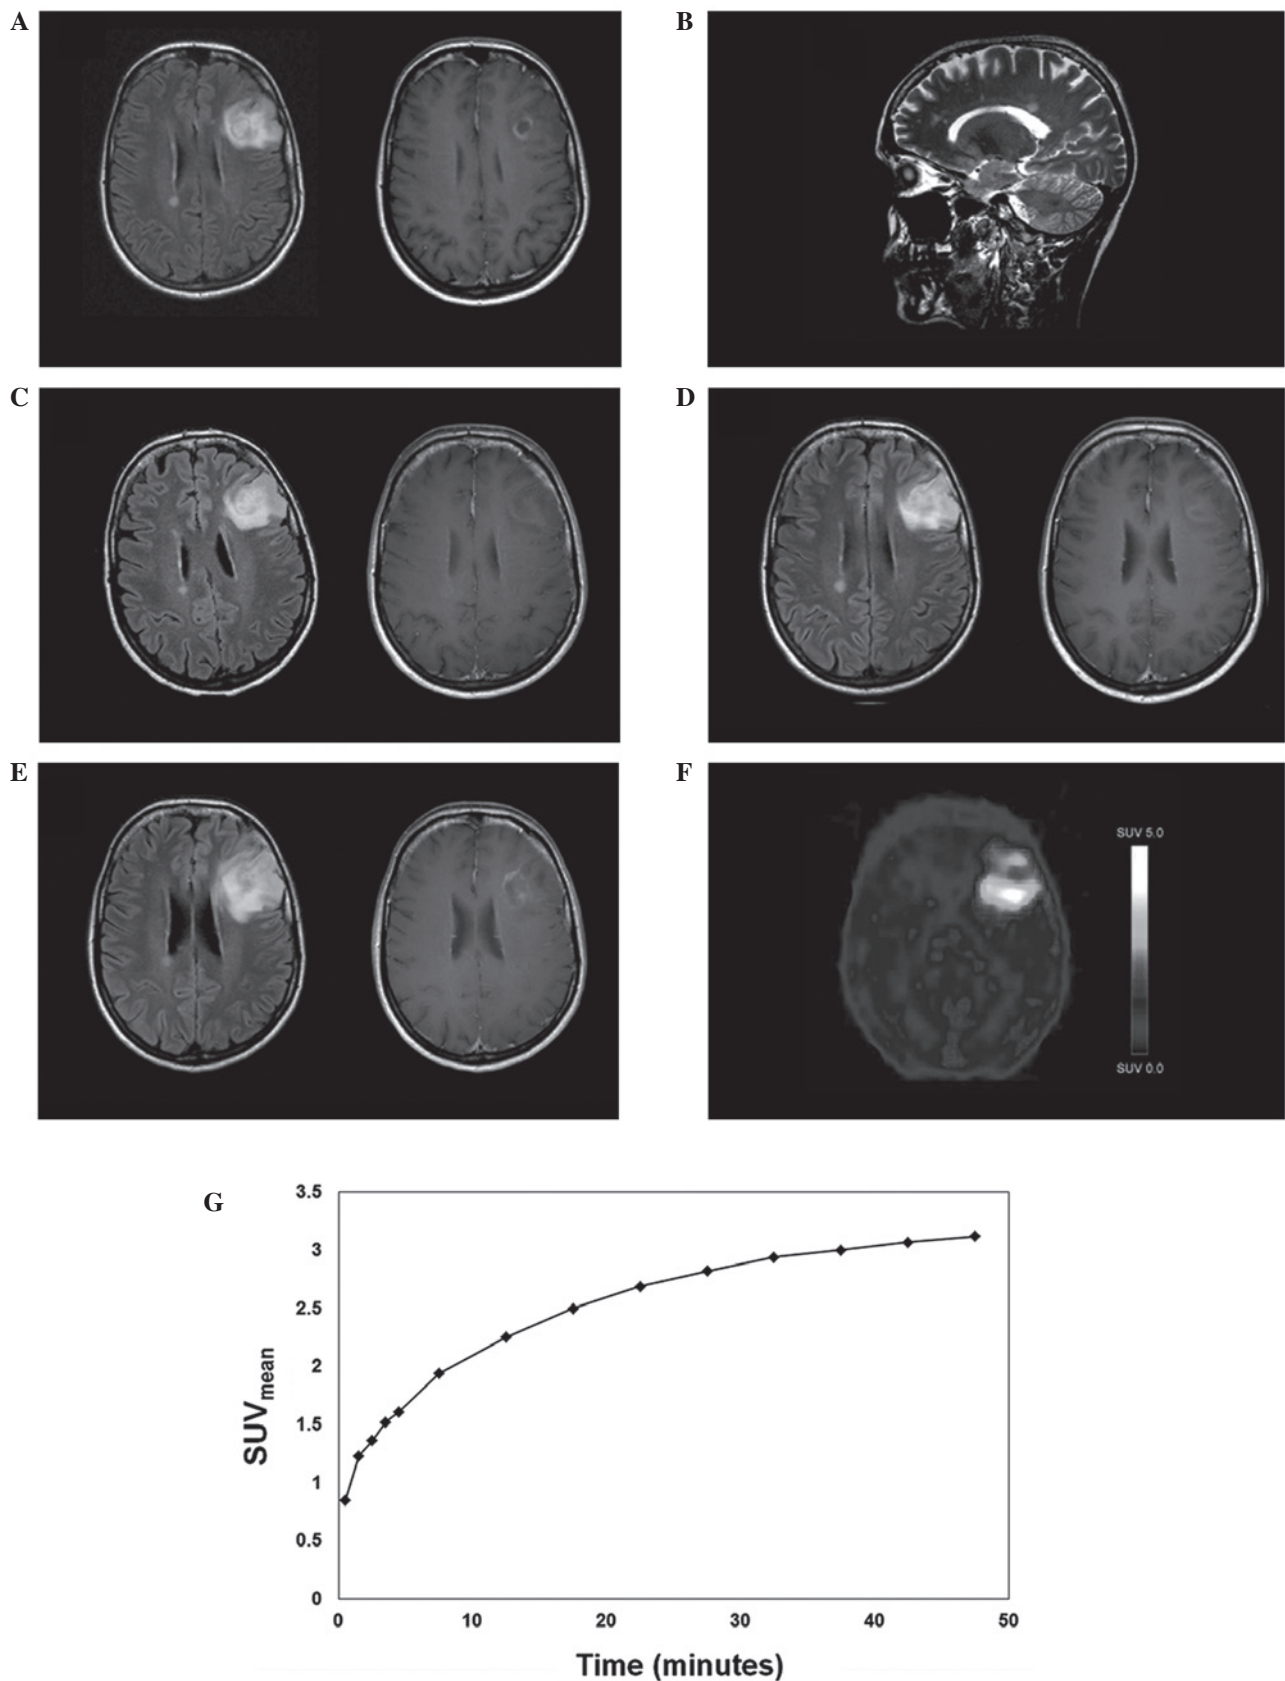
MRI and ^{18}F -FET PET imaging. (A) MRI scans at patient's initial presentation with several small periventricular hyperintense lesions and a large left frontal lesion on axial FLAIR imaging (left) with ring-shaped enhancement on T1-weighted (right) spin echo sequences following intravenous administration of gadolinium. (B) Persisting linear and ovoid lesions in the periventricular white matter on a sagittal T2-weighted turbo spin-echo sequence. (C) Sustained response and (D) size decrease of the hyperintense lesion on FLAIR (left) and T1-weighted (right) imaging following contrast, observed over a course of 3 years in response to corticosteroid pulse treatment. (E) 3 years later, another increase in size observed on FLAIR (left) and T1-weighted (right) pulse sequences following contrast administration. (F) ^{18}F -FET PET imaging showing high ^{18}F -FET uptake in the left frontal lesion with (G) initial rapid increase in SUV_{mean} followed by slower further tracer accumulation. MRI, magnetic resonance imaging; ^{18}F -FET, ^{18}F -fluoroethyl-L-tyrosine; PET, positron emission tomography; FLAIR, fluid attenuated inversion recovery; SUV_{mean} , mean standardized uptake value.
